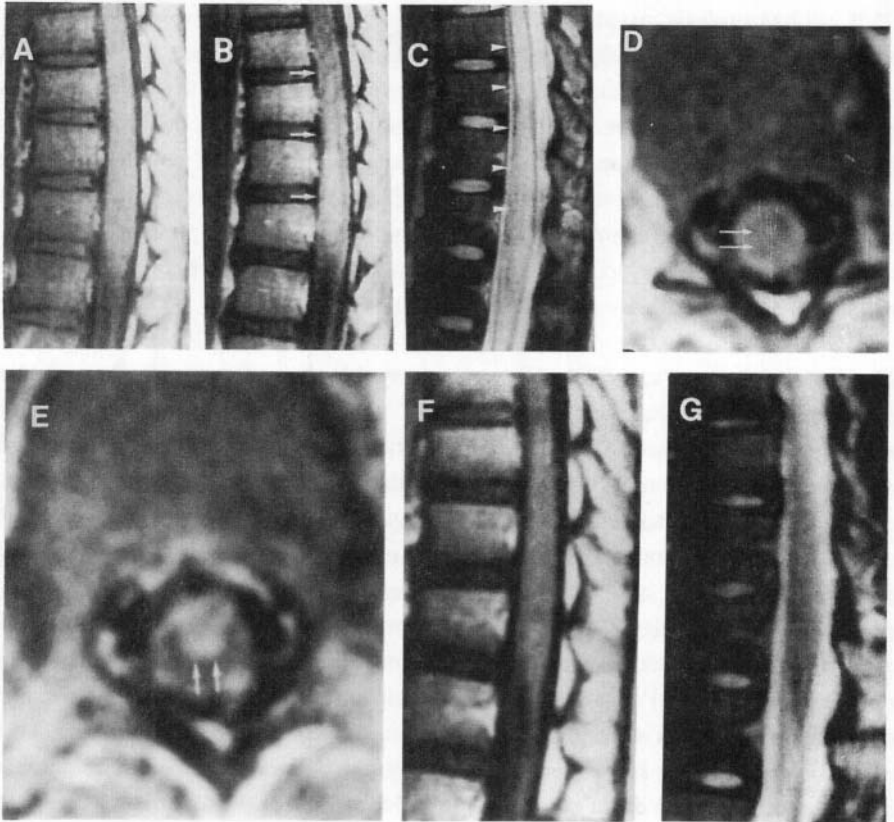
Schistosoma mansoni* intramedullary abscess. T1-weighted sagittal and axial images before (a and d) and after (b and e) contrast administration show widened anteroposterior and transverse dimensions of the spinal cord with low central signal intensity (arrows, d) and with intramedullary contrast enhancement (arrows, b and e), most prominent anteriorly. The initial T2-weighted image (c) shows abnormal high signal in the distal cord and conus (arrowheads). Five months later, there is no persisting enhancement after contrast enhancement (f), and signal intensity on T2-weighted image is normal (g). (Reprinted with permission from Murphy KJ, et al. *Am J Neuroradiol* 1998; 19: 341–348.)
